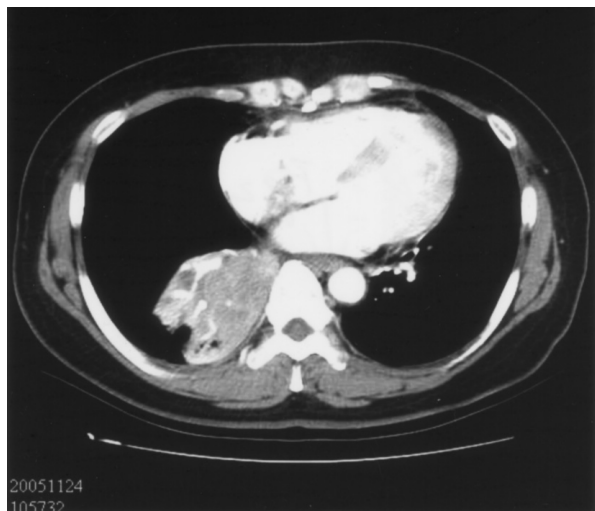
Chest CT reveals right lower lobe collapse
